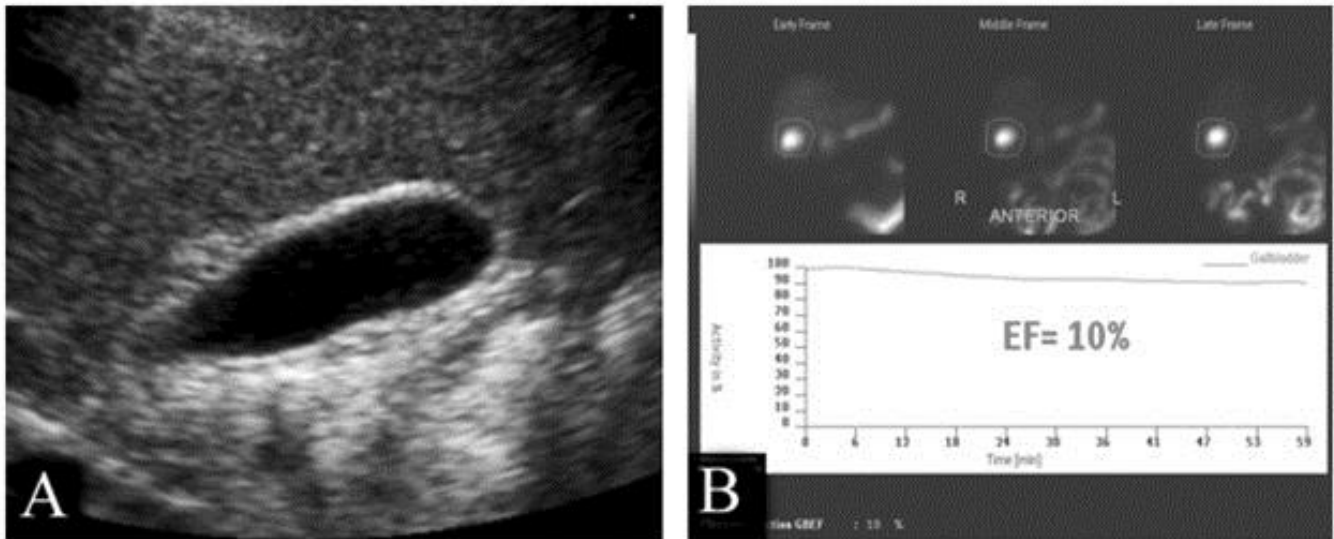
Sphincter of Oddi dysfunction in a 50 year old man with chronic right upper quadrant postprandial pain. A. Ultrasound study of the gallbladder is normal. B. Nuclear medicine hepatobiliary scan shows an abnormally diminished ejection fraction. The patient underwent elective cholecystectomy with relief of his symptoms.
